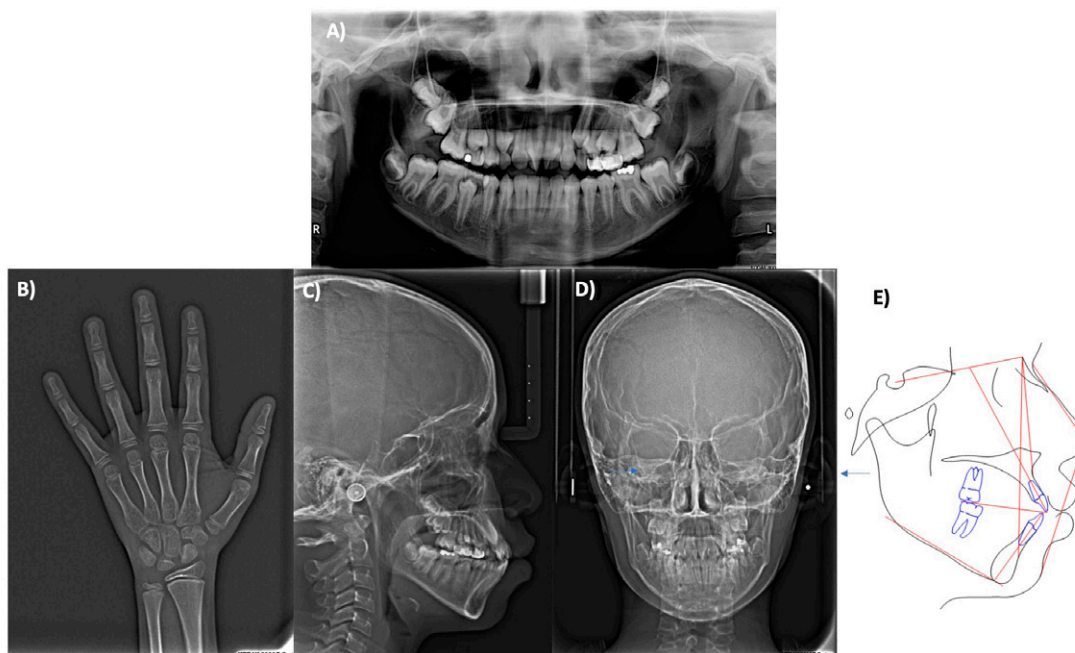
Imaging studies. A) Orthopantomography. B) Carpal radiography. C) Lateral head film. D) Posteroanterior radiograph. E) Steiner cephalometric tracing.
